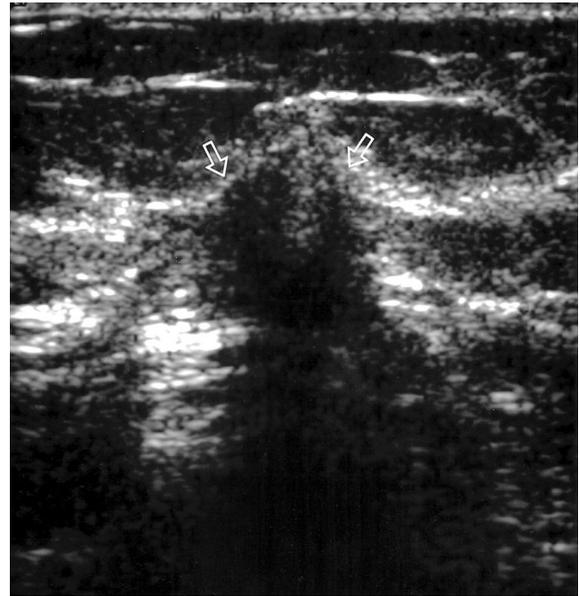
Ultrasonogram of the left breast revealing a 1.5 cm sized, ill-defined, and irregular hypoechoic lesion with posterior shadowing (arrows) in the 10 o'clock position in the left breast, 3 cm away from the nipple.
